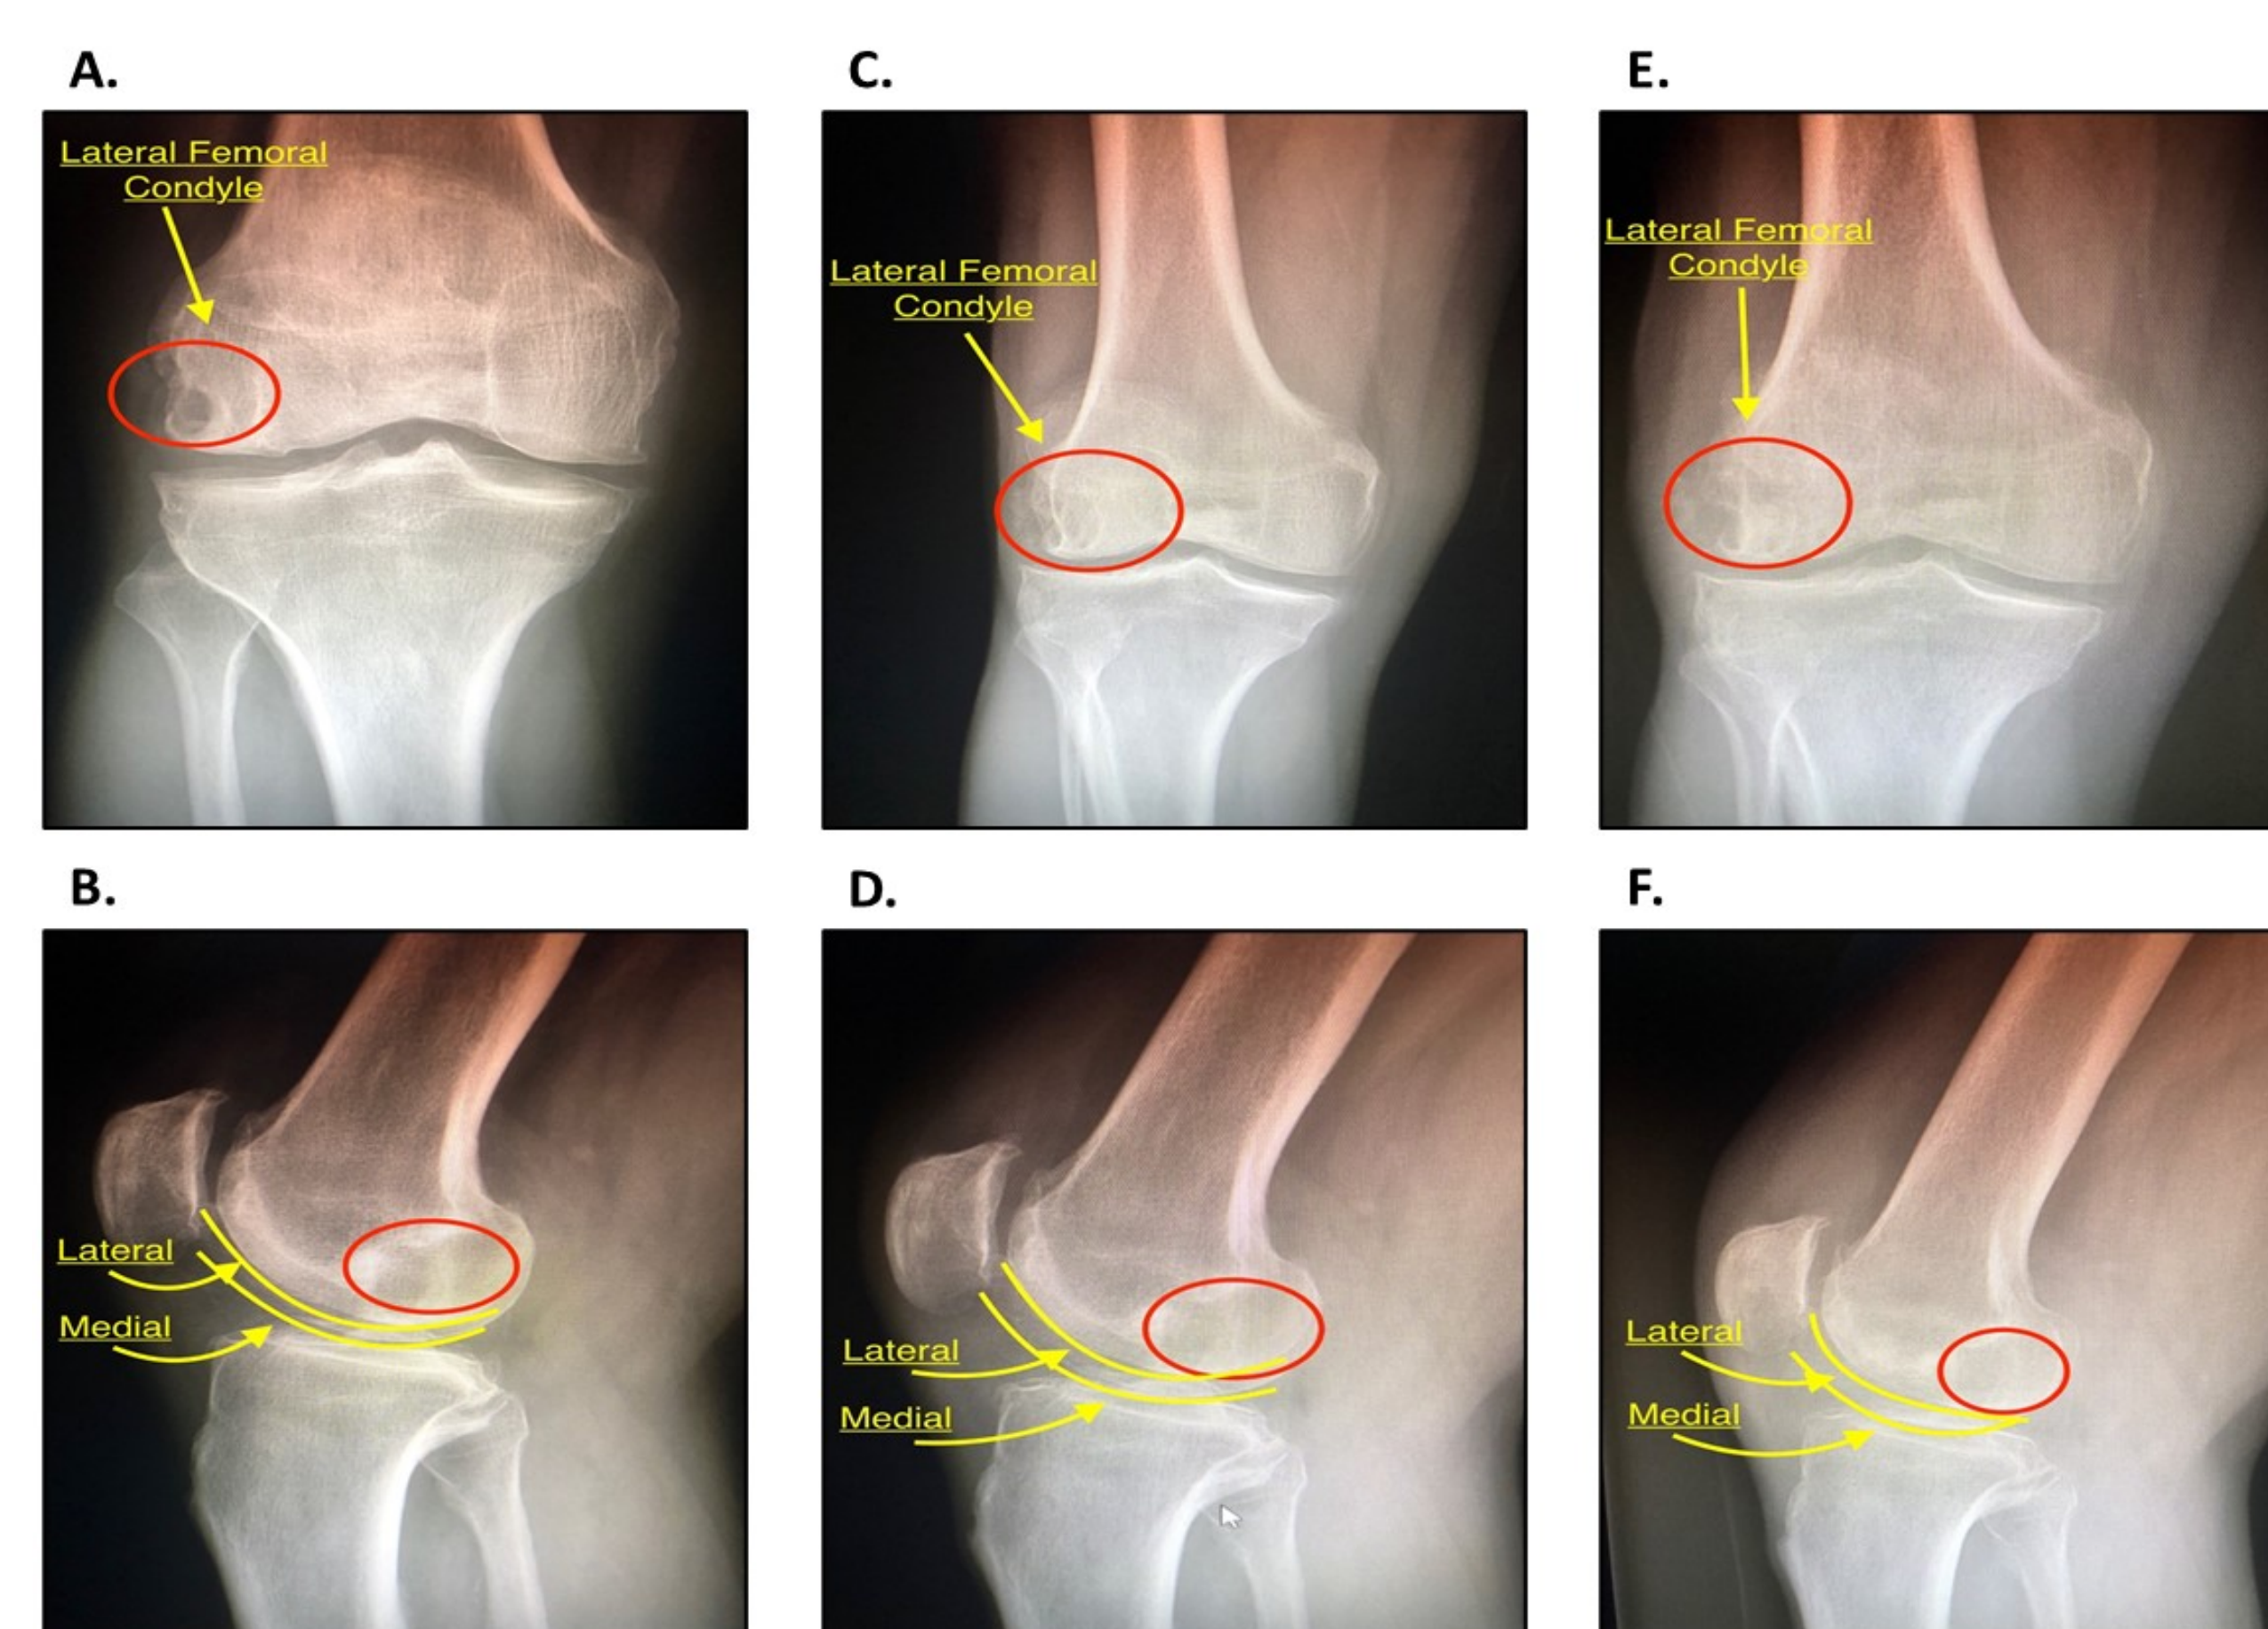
(A) AP radiograph of the right knee, pre-operative. The lateral femoral condyle can be visualized with the area of decreased opacity representing the SC (red circle). The joint space is well preserved with mild patellofemoral OA with osteophytes. (B) Lateral radiograph of the right knee, pre-operative. The red circle depicts the same SC. The lateral and medial femoral condyles are outlined in yellow. Both 6A and 6B will be used as a baseline for comparison. (C) AP radiograph of the right knee 3 months following IOBP. The lateral femoral condyle can be visualized with signs that the area of the previous SC is filling (red circle). (D) Lateral radiograph of right knee 3 months following operation. The red circle depicts the area of the SC. (E) AP radiograph of the right knee 6 months following IOBP. The area of the previous SC (red circle) has increased in opacity in comparison to the previous image at 3 months. (F) Lateral radiograph of the right knee six months following IOBP. The area of the previous SC (red circle) is more opaque, an indication that there is progressing filling of the previous lesion. This suggest that the IOBP has been successful.
